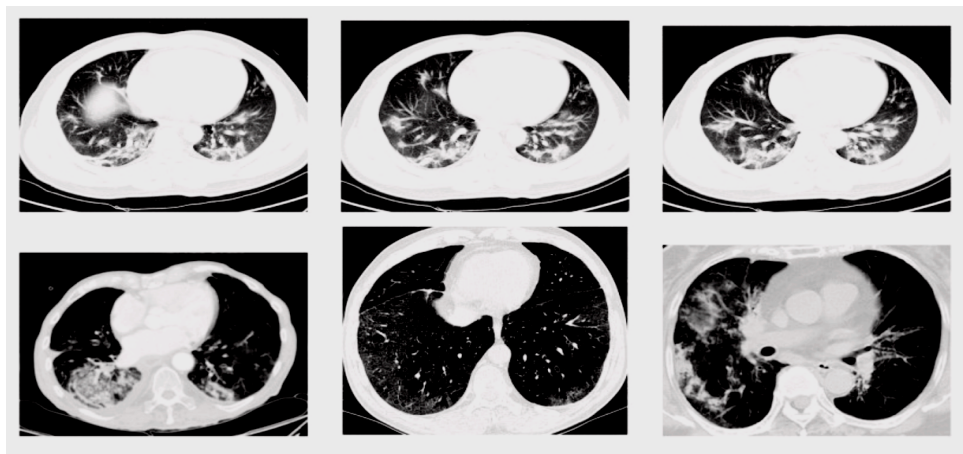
CT scans COVID-19 (top) and normal (bottom) [5].
